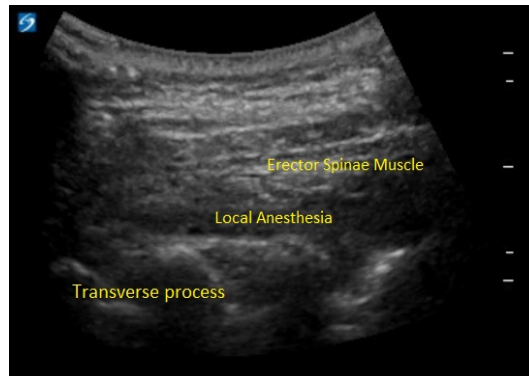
Ultrasound showing local anesthetic spread in the erector spinae fascial plane.
